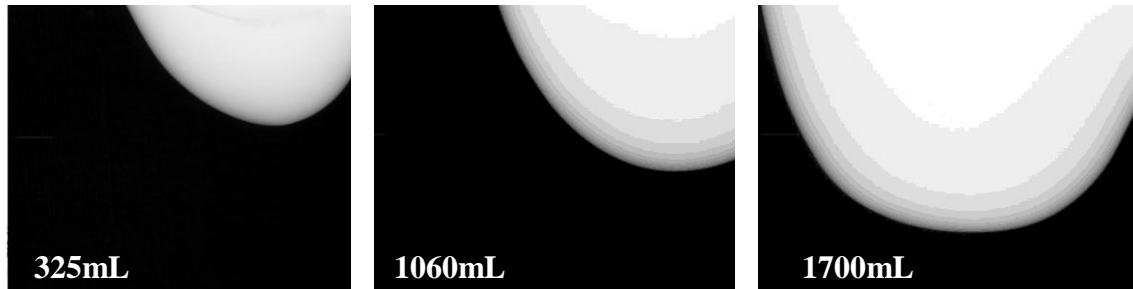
Sample projections of the three breasts acquired in position A. X-ray exposure is kept constant at 2.5mAs. For the image gray scales, dark means high exposure (pixel value), and lighter means less exposure.
